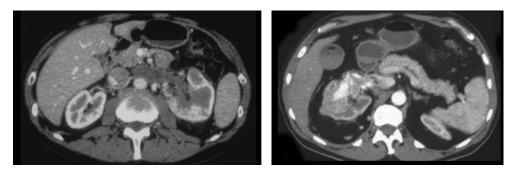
Renal cell carcinoma - T3b.N1.V2.Mx - CT exam with contrast substance:
